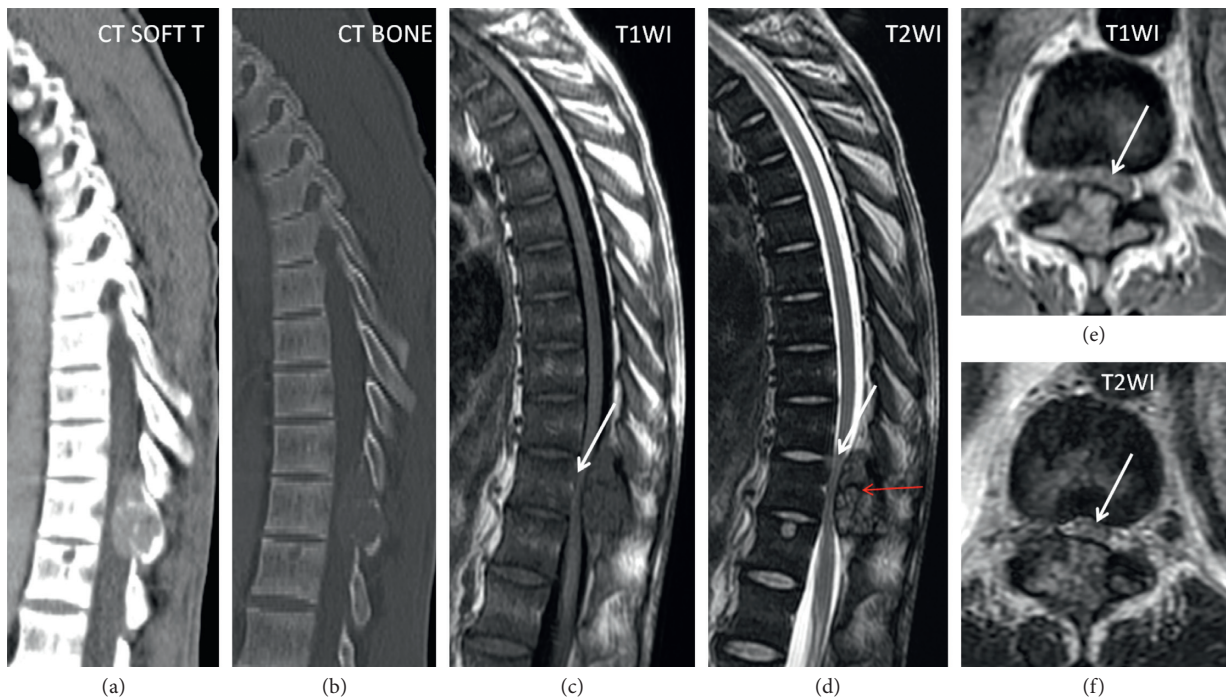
Thoracic spine brown tumor. Sagittal CT, sagittal T1WI/T2WI, and axial T1WI/T2WI MRI sequences show an expansile, well-circumscribed lesion in the posterior elements extending within the spinal canal, with severe spinal canal stenosis and compressed spinal cord (white arrow). Areas of low signal on T2WI from hemosiderin are indicated by the red arrow.
